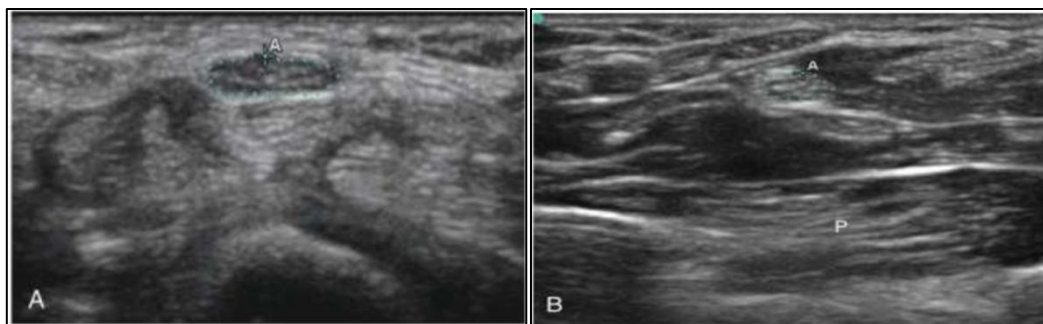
Carpal Tunnel Syndrome: Measurement Technique. Ultrasound images in short axis to the median nerve at the level of (A) carpal tunnel and (B) pronator quadratus (P) show the circumferential trace method of calculating median nerve area (see caliper markings).
